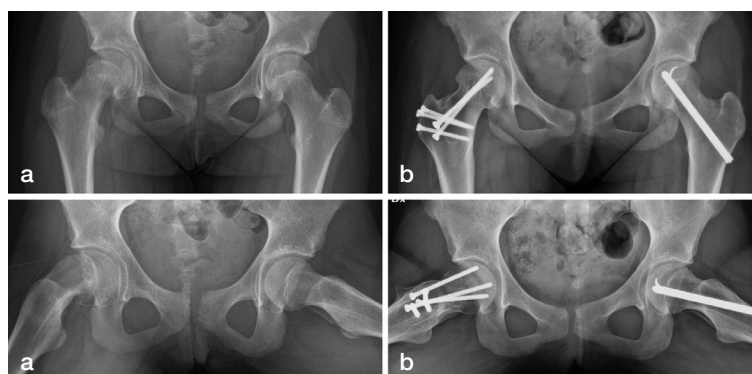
Radiographs (a) of a 12-year-old girl with a 4-month history of hip-related symptoms show a right-sided, severe, stable SCFE (slip angle 60°). The girl underwent modified Dunn surgery at diagnosis, with simultaneous prophylactic nailing on the contralateral side. At 2-year follow-up, the patient reported excellent outcome with normalized hip function (b).
